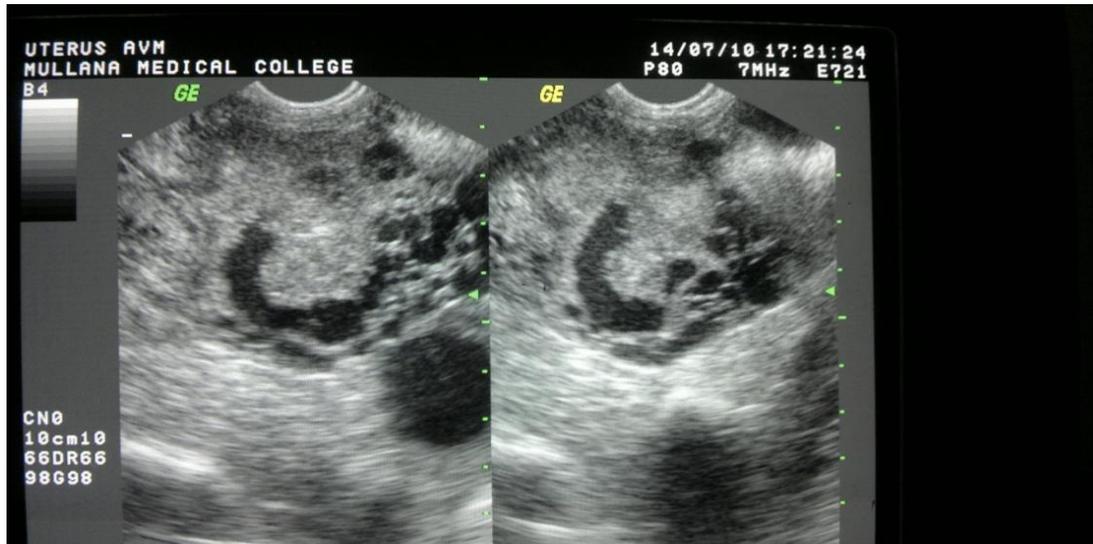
Ultrasound Transverse view showing retained products of conception with AV Malformations.
